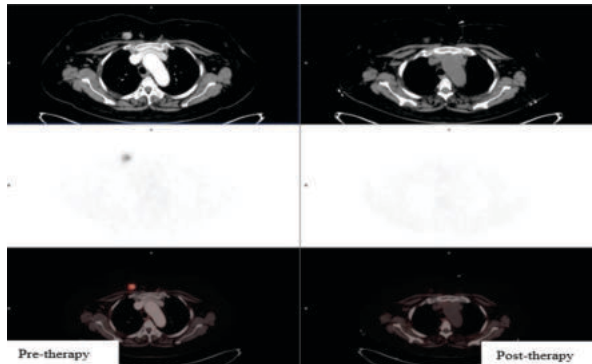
DOTA PET-CT scan shows reduction in the SSTR expression at the primary breast lesion post 2 months of therapy
